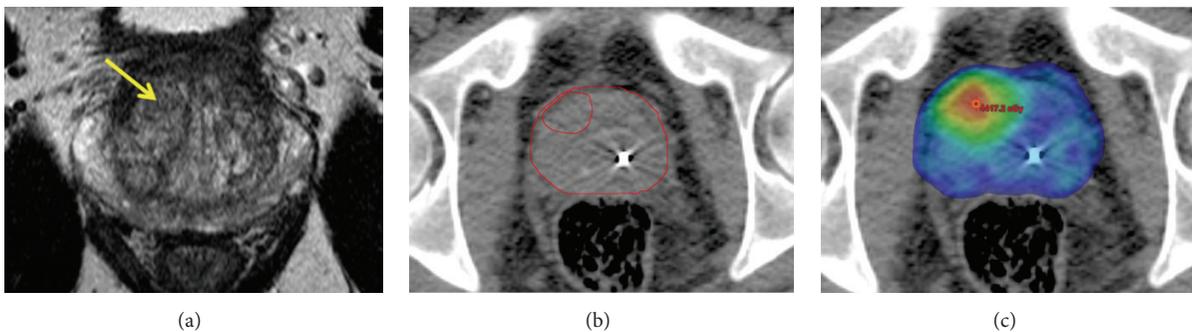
Axial views of the patient in Figure 1 with Gleason 3 + 4 disease found in right mid anterior central gland using MRI-TRUS fusion biopsy. The T2 hypointense lesion is shown in (a) with clinical target volumes drawn around the prostate and nodule on axial CT in (b). A 36 Gy dose colorwash to the whole prostate and simultaneous integrated boost of 40 Gy to the T2 hypointense lesion using an extreme hypofractionation radiation treatment plan are shown in (c). Note the fiducial markers used for daily image-guided localization.
